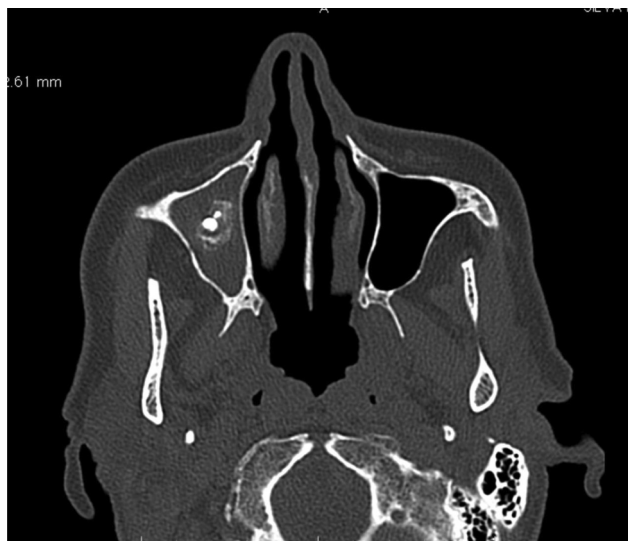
A CT scan showing sealer overfilling in the right sinus appeared as a hyperdense structure surrounded by a peripheral opacification.
